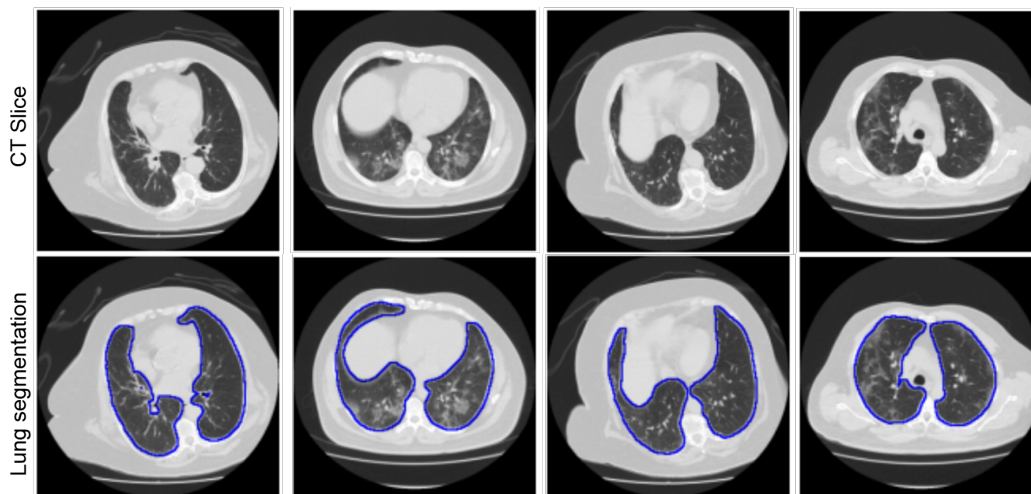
Lung segmentation in CT Chest slice. The first row corresponds to CT slice. In the second row, images correspond to lung segmentation overlapped in whole CT slice.
